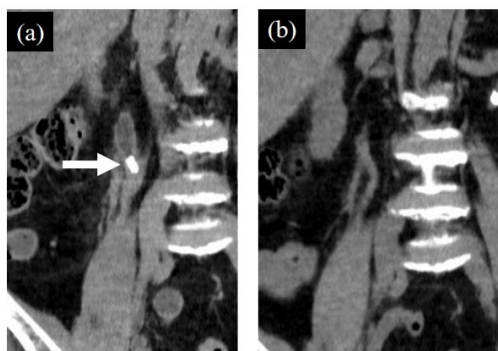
CT imaging of a 61-year-old woman with successful ESWL outcome. A pre-operative imaging (a) showed a 10.4-mm right proximal ureteric stone (arrow). A follow-up imaging after ESWL treatment (b) showed disappearance of the aforementioned stone.
